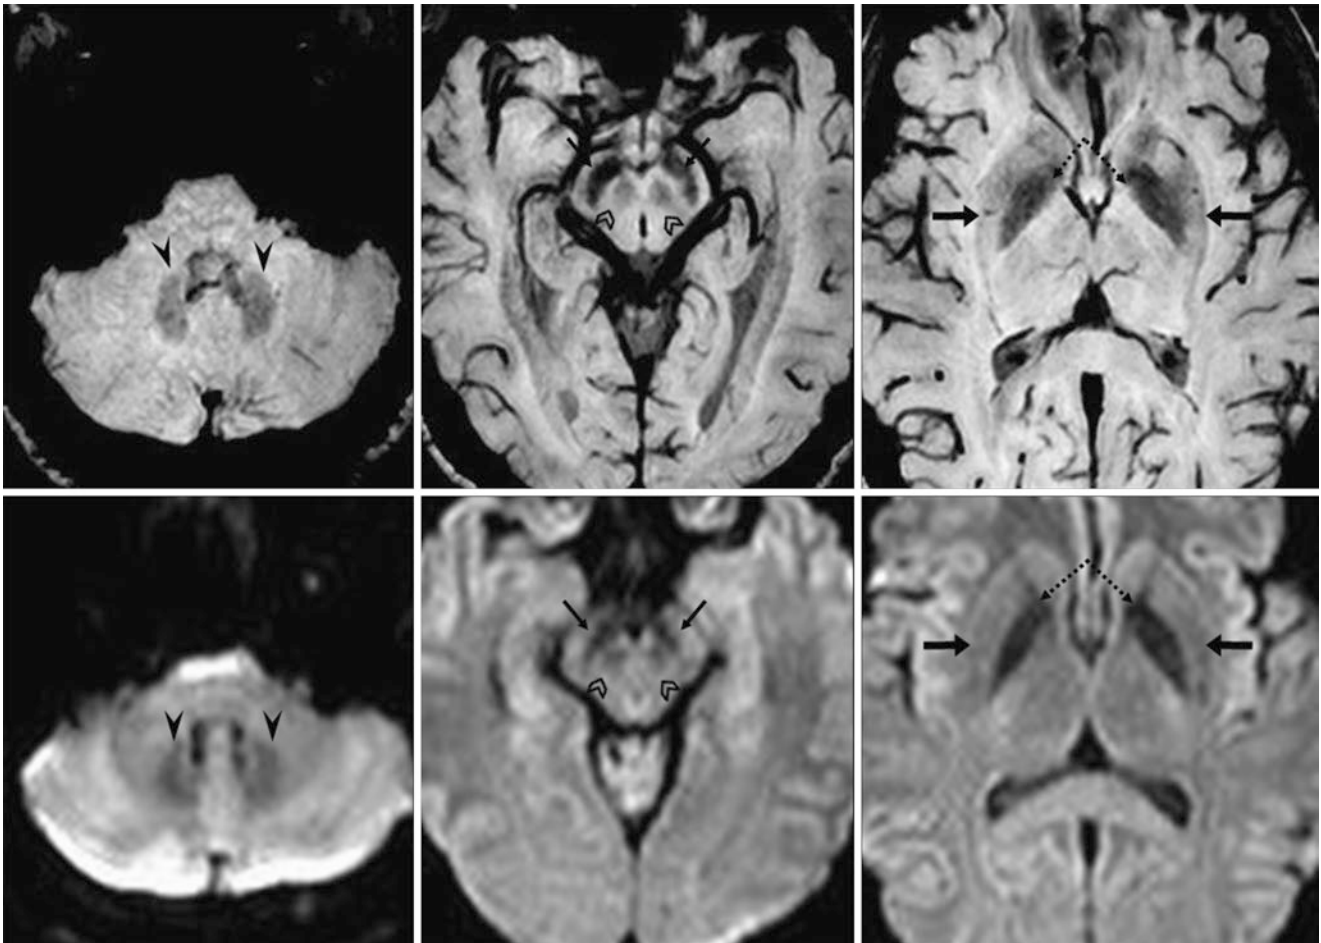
A 39 year old with a negative 3T MRI for headaches. SWIs (*top row*) show iron deposition within the dentate nuclei (*arrowheads*), SN (*thin arrows*), GP (*dotted arrows*), putamina (*arrows*), and red nuclei (*chevrons*). The putamina have become darker in signal as iron continues to accumulate (*arrows, right*). These nuclei are also dark on DWIs (*bottom row*) because of the iron's susceptibility effects
